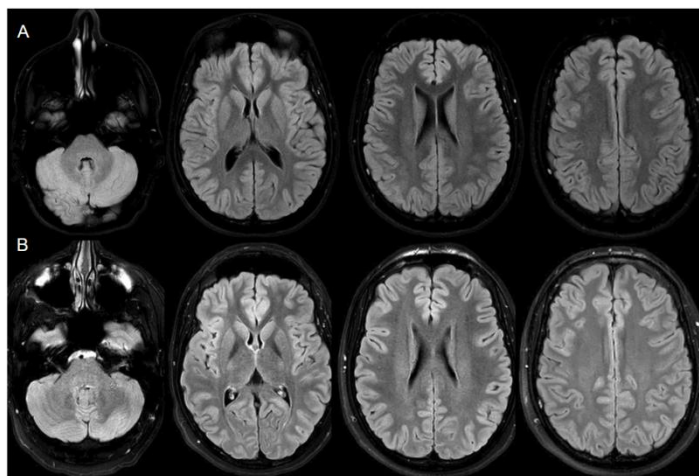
Comparison between the MRIs performed at the hospitalization (A) and after 4 months (B): FLAIR images show persistent absence of abnormalities.
